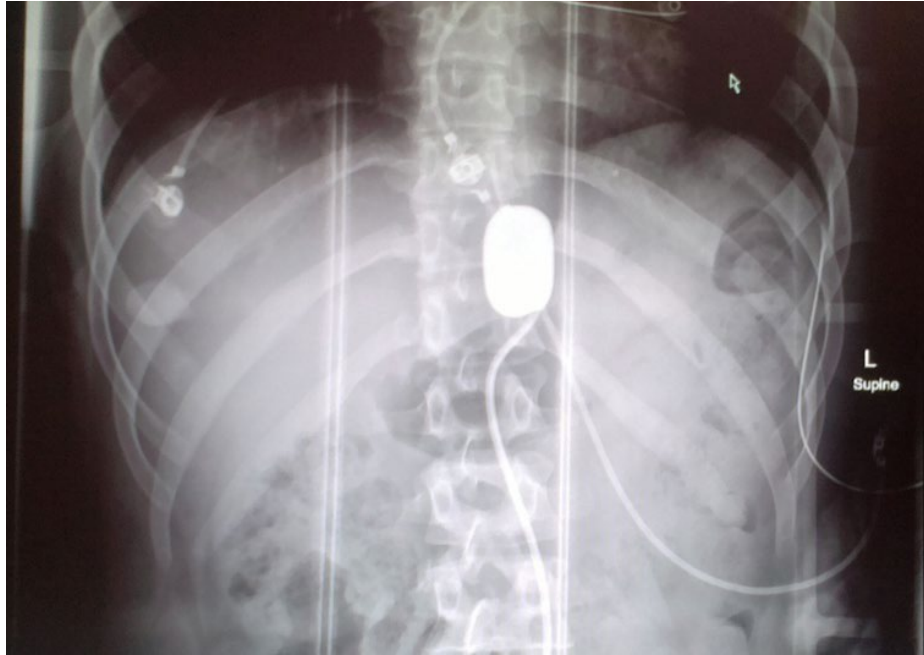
Abdominal Xray of a Zone I level deployment for both intra-abdominal and pelvic haemorrhage (1st Case at Royal Perth Hospital, 6 October, 2014)
